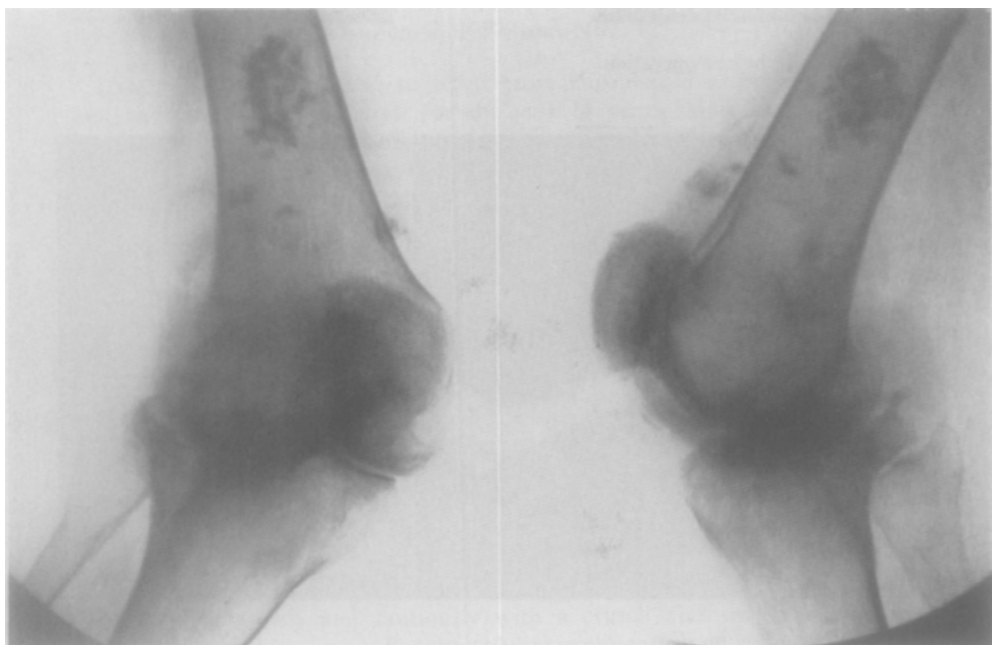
Case 1: preoperative roentgenograms of right knee.
